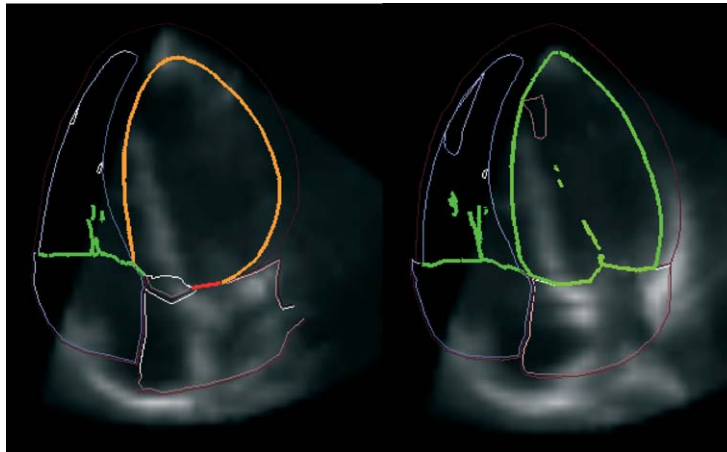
According to the quality of the image plane the contours of the landmarks are colored. In the left image the LV is sub optimally visualized, the mitral valve poorly and the tricuspid valve well. After accurate adjustment of the image plane all landmarks are colored green indicating a perfect apical four-chamber view. Note that the contours of the heart model and the ultrasound image are not absolutely congruent due to the inherent inaccuracy of the registration of individual 3D ultrasound data sets to a non-deformable heart model.
